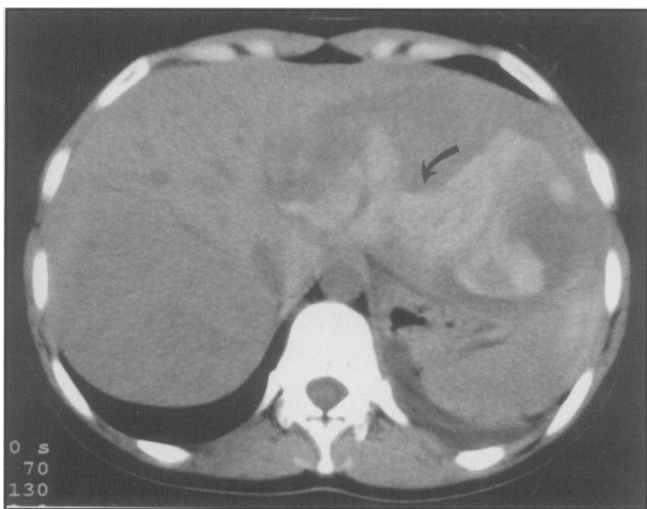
CT scan, from patient 1, demonstrating a large heterogeneous lesion in the left lobe, into which bleeding has occurred (curved arrow).
